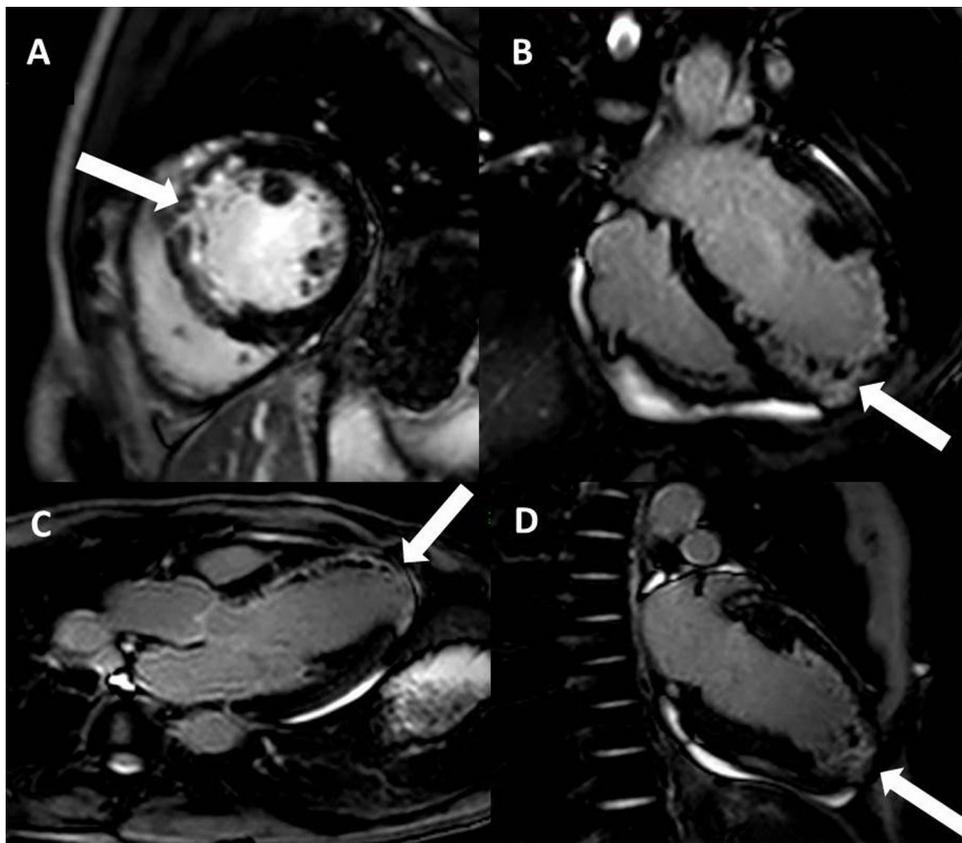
Heart magnetic resonance imaging with late gadolinium enhancement. (A) Short-axis view, (B) 4 cavities view, (C) 3 cavities view, and (D) 2 cavities view. Arrows show myocardial necrosis zones.
